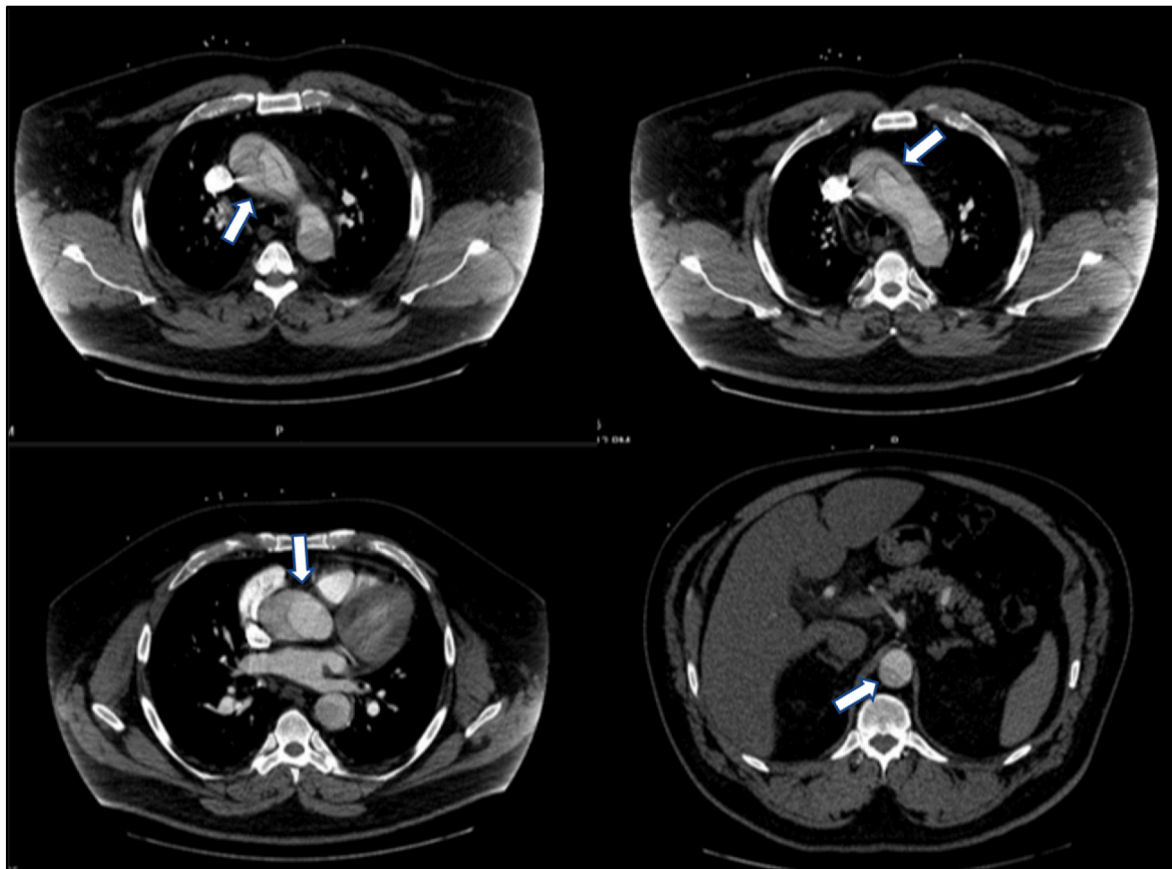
CTA Images: Stanford type A, dissection involving the ascending aorta, aortic arch, and descending aorta down to the level of the celiac trunk (White Arrows).
